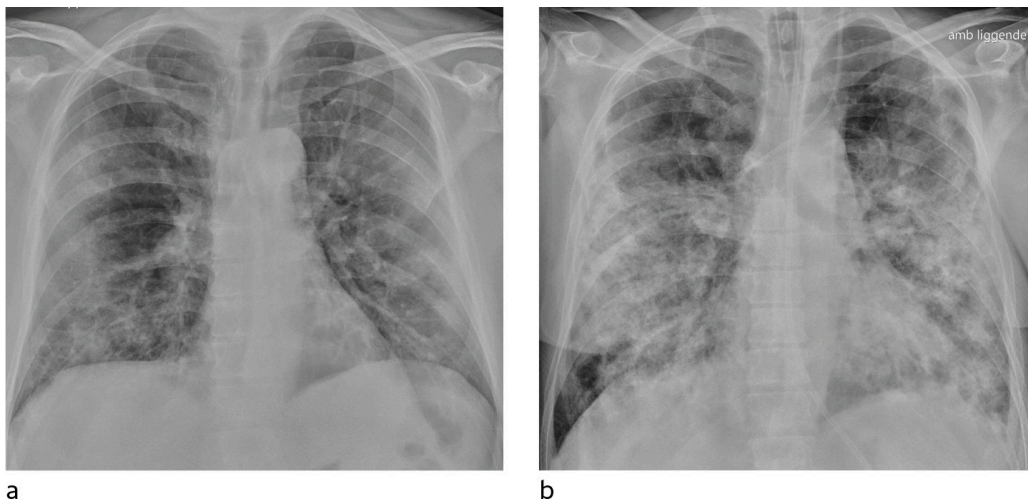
a) Patient with COVID-19. Bedside chest X-ray 10 days after symptom onset shows predominantly patchy opacities bilaterally, most distinct peripherally. Because of increasing hypoxia and fatigue the patient was intubated two days later. b) Prone chest X-ray 20 days after symptom onset shows considerable progression with increasing consolidation. There is still little or no pleural fluid. The picture also shows a nasogastric tube, central venous catheter and endotracheal tube.
